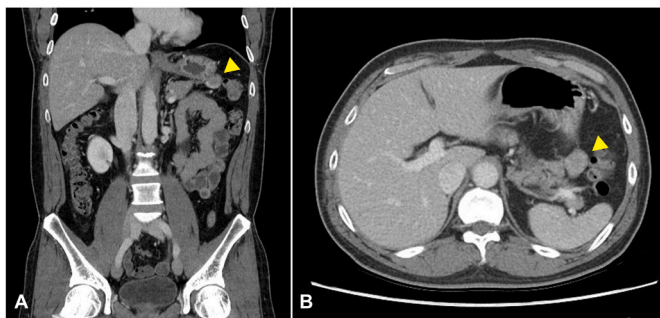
Abdominal computed tomography image during routine health screening. (A) Coronal view shows a mass-like lesion abutting the stomach, which was suspected to be continuous with the gastric mucosa (yellow arrow). (B) Axial view shows slightly heterogeneous mass with low attenuation without significant enhancement (yellow arrow). (For interpretation of the references to colour in this figure legend, the reader is referred to the Web version of this article.)
